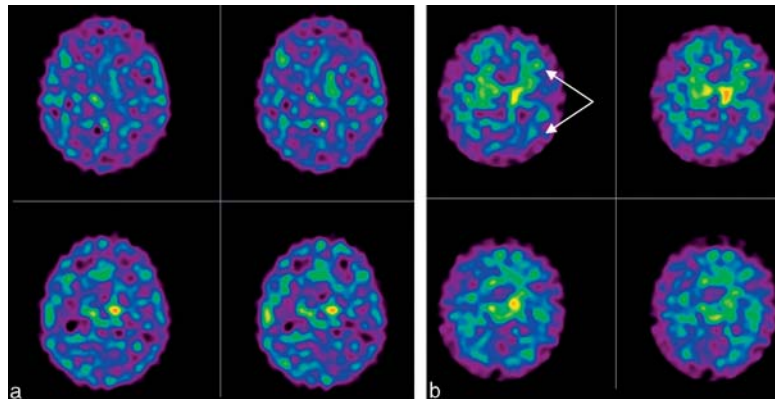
Transaxial SPECT images of ^{123}I IMPY: (a) in an elderly control subject; (b) in a patient with Alzheimer's disease (AD). There is substantially greater binding in the cortex in the AD patient than in the control (arrows).
